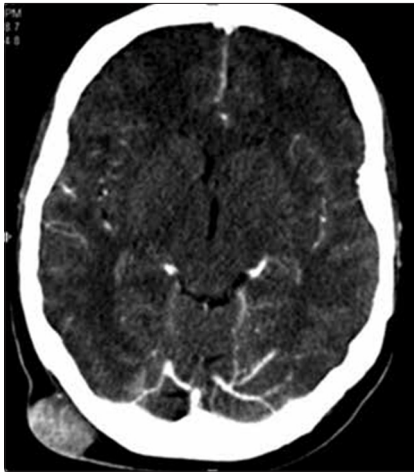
Computed tomography scan of subcutaneous mass
